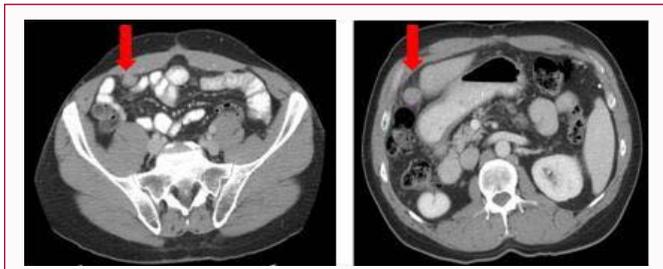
Case B. CT 05/22/2005, reveals two abnormal intra-abdominal foci (red arrows) concerning for recurrent disease.
